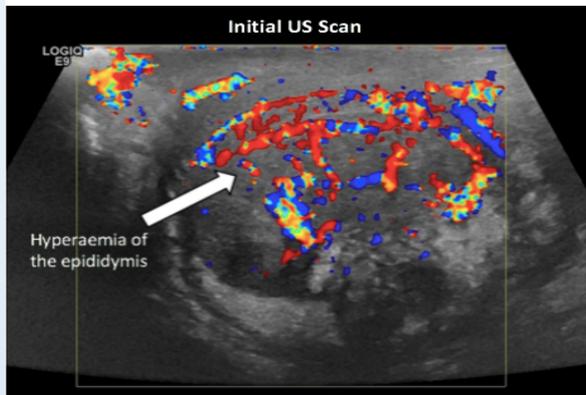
The right epididymis appeared enlarged with an oedematous and hyperaemic sonographic appearance suggestive of epididymitis (Suciu *et al.* 2017).
